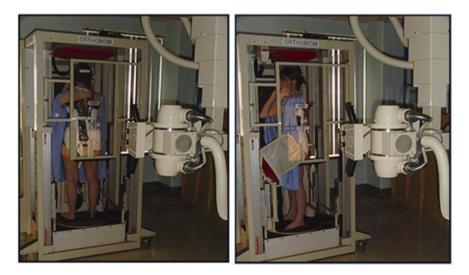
One of the first 3D reconstruction systems installed at the Sainte-Justine Hospital in 1992, where a plexiglass cage with embedded pellets is used to calibrate the X-ray scene. The patient is turned from the frontal to sagittal position to obtain biplanar radiographs
